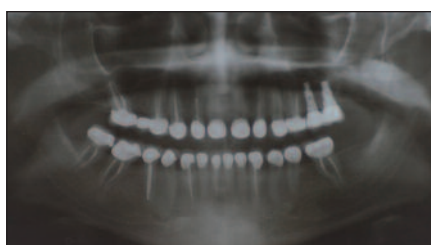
Postoperative panoramic radiograph (Panorex).
